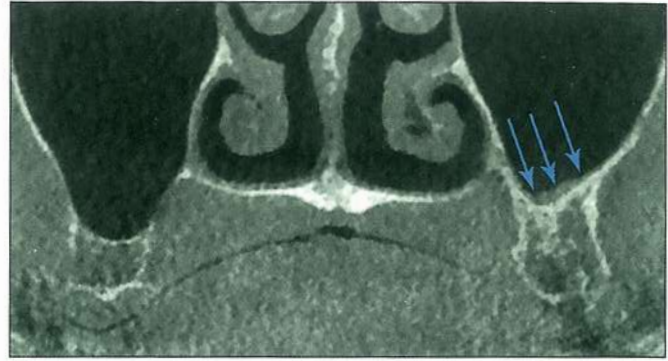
Coronal CBCT image of a slightly thickened sinus membrane (*arrows*).
